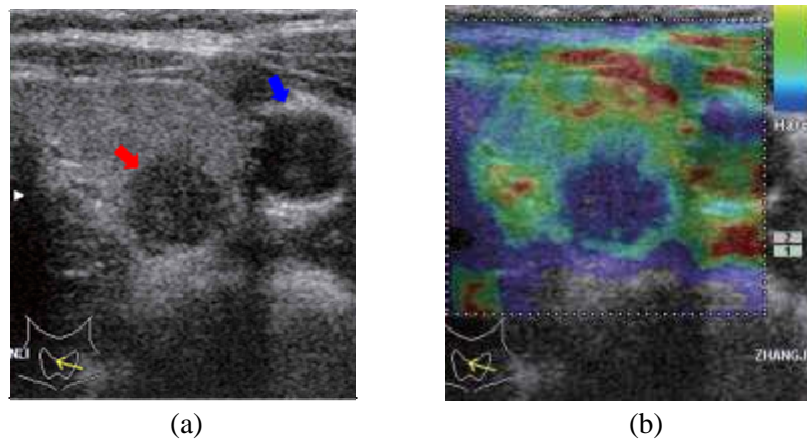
(a) Ultrasound B-mode image and (b) the corresponding elastography image of a papillary thyroid carcinoma. An invasive papillary thyroid carcinoma and the carotid artery are pointed by red and blue arrows, respectively.
